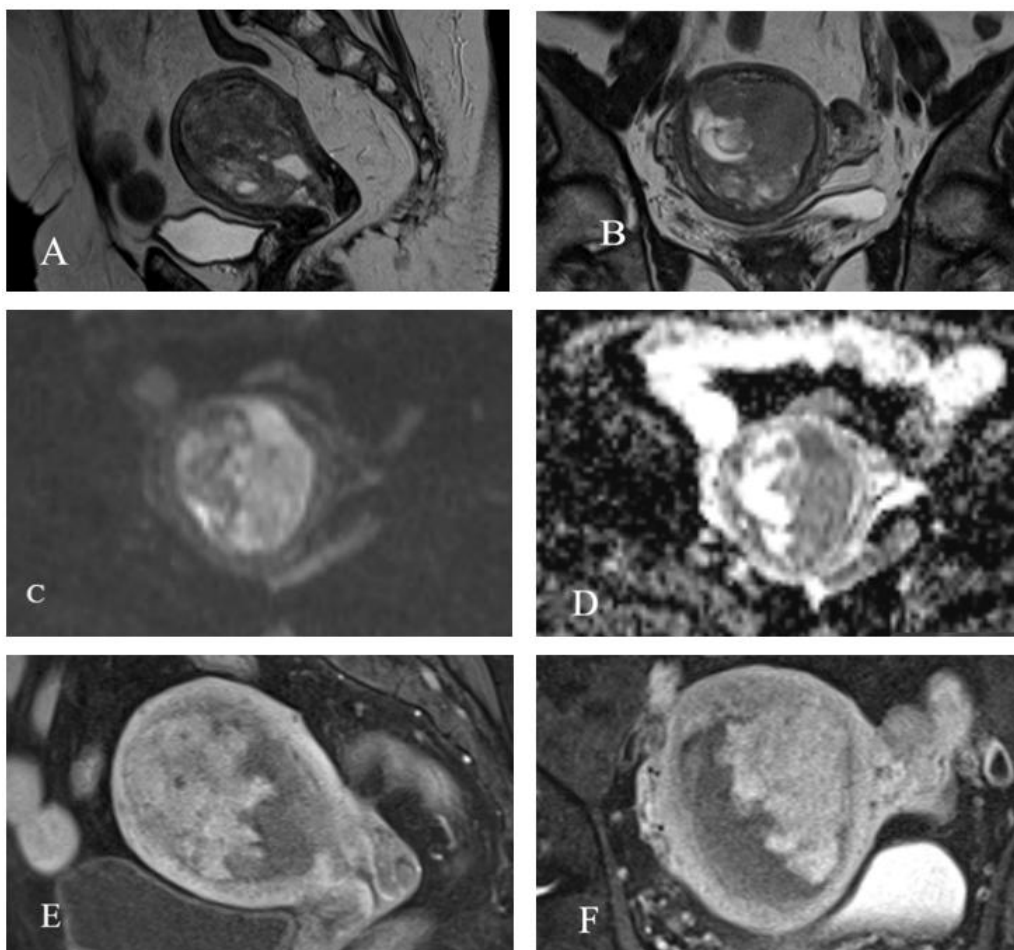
A 70 - year - old female with endometrial carcinoma. T2 Weighted Images (A) Sagittal and (B) Coronal sections shows endometrial thickening with heterogeneously hyperintense lesion with few cystic areas within. (C) DWI and (D) ADC
